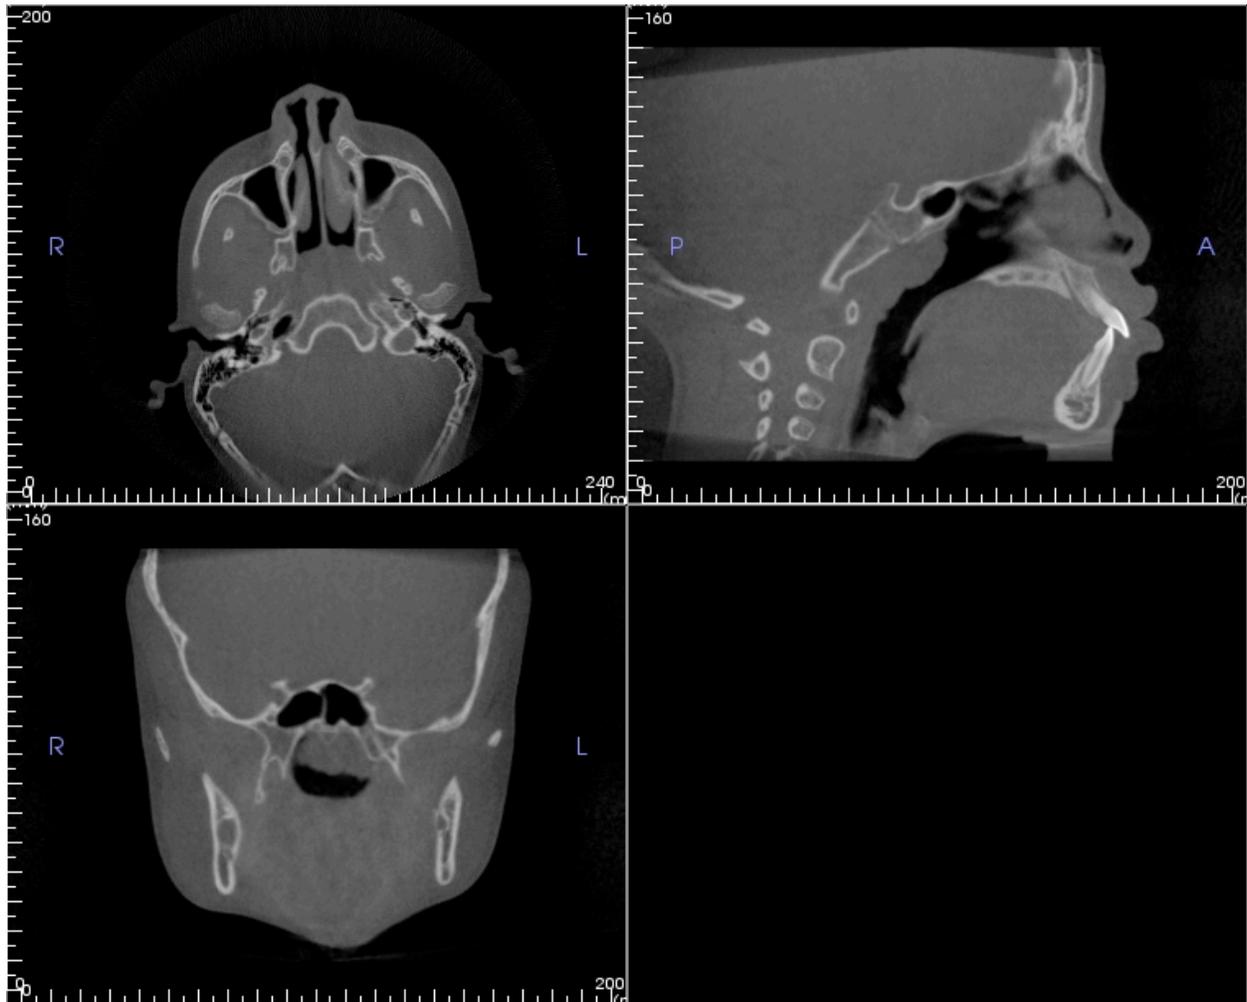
Axial, sagittal and coronal slices of the initial CBCT image prior to reorientation.
